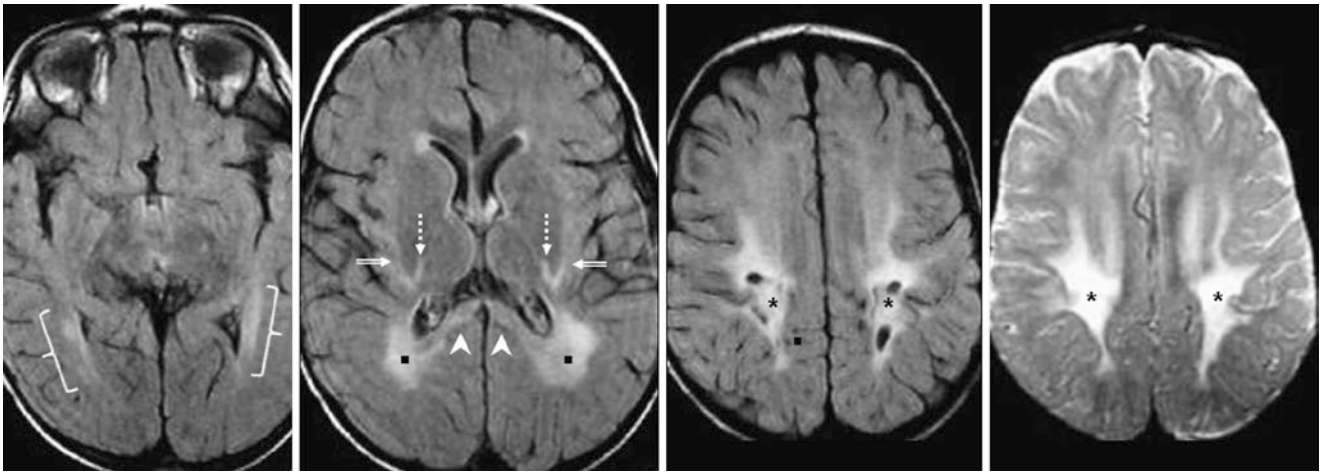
Comparison case of globoid leukodystrophy (GLD, Krabbe disease). A 23-month-old had a 1.5T MRI that showed abnormal signal and cystic leukomalacia of peritrial WM (squares), optic radiations (brackets), supraventricular WM (asterisks), SIWM (beveled
